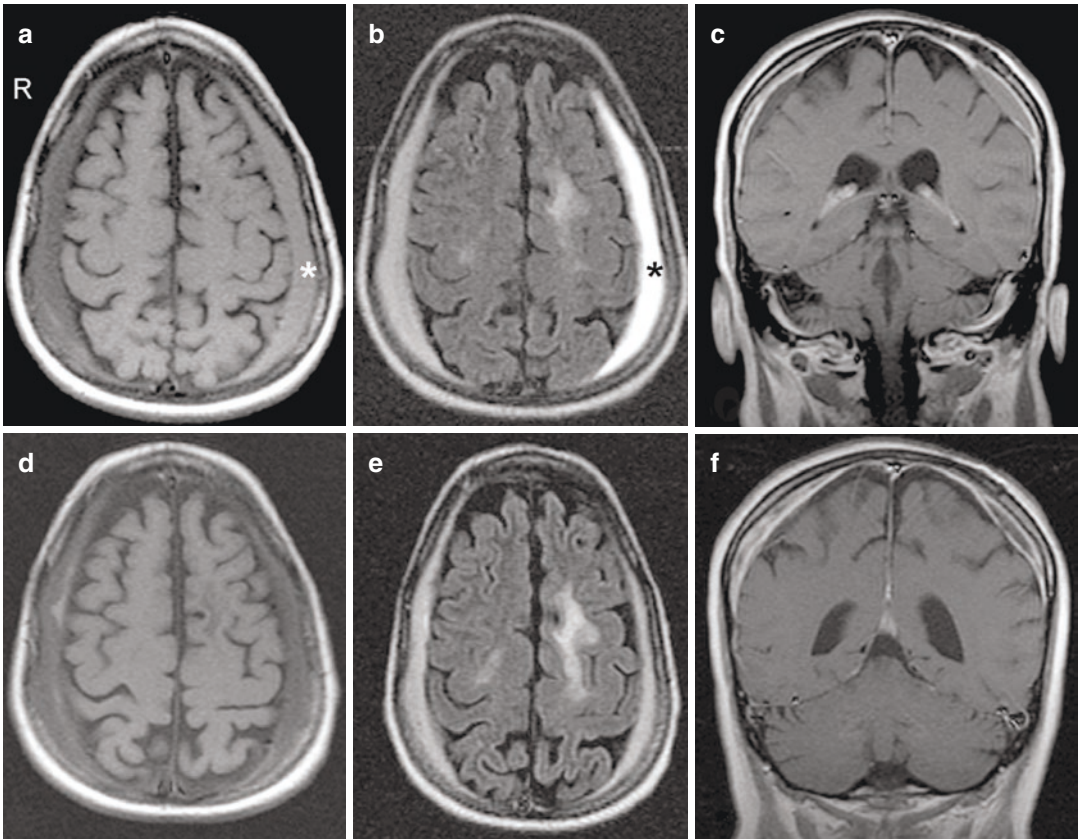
MRI of SDH. (a) Axial T1-weighted MR image, performed on a 0.7 T open MRI, reveals bilateral holo-hemispheric SDHs. The subacute left SDH has signal intensity relatively higher than adjacent parenchyma due to the presence of methemoglobin. (b) The corresponding FLAIR image shows that the subacute left SDH is quite intense. The chronic right SDH has signal intensity higher than the suppressed CSF signal. (c) The SDHs also have enhancing capsules, as seen on the coronal T1-weighted
